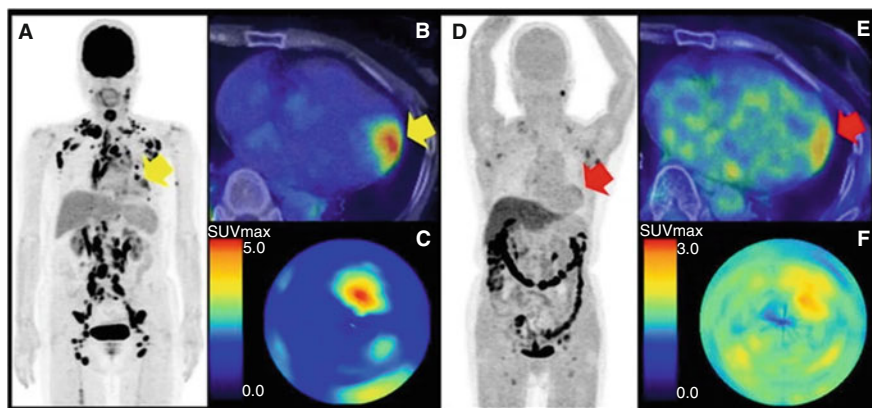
Imaging cardiac sarcoidosis with [^{18}F]FMISO. [^{18}F]FDG (a–c) and [^{18}F]FMISO (d–f) PET/CT images: MIP image, fusion image, and polar map image of a patient with metastatic papillary thyroid cancer. This patient fasted for more than 18 h prior to [^{18}F]FDG administration to suppress the physiological uptake of [^{18}F]FDG in the myocardium. (a) Multiple areas of [^{18}F]FDG uptake are visible, making it difficult to distinguish metastases from sarcoidosis lesions. (d) [^{18}F]FMISO showed focal uptake in some of the [^{18}F]FDG-positive lymph nodes (d). In addition, a focal uptake of [^{18}F]FDG (yellow arrow; SUV_{max} 5.1) was detected at the anterolateral wall, indicating active inflammatory change associated with sarcoidosis (b, c). [^{18}F]FMISO PET also showed the abnormal uptake (red arrow; SUV_{max} 2.8) in the same cardiac region (e, f). Adapted from [130] with permission. © 2016, American Society of Nuclear Cardiology
